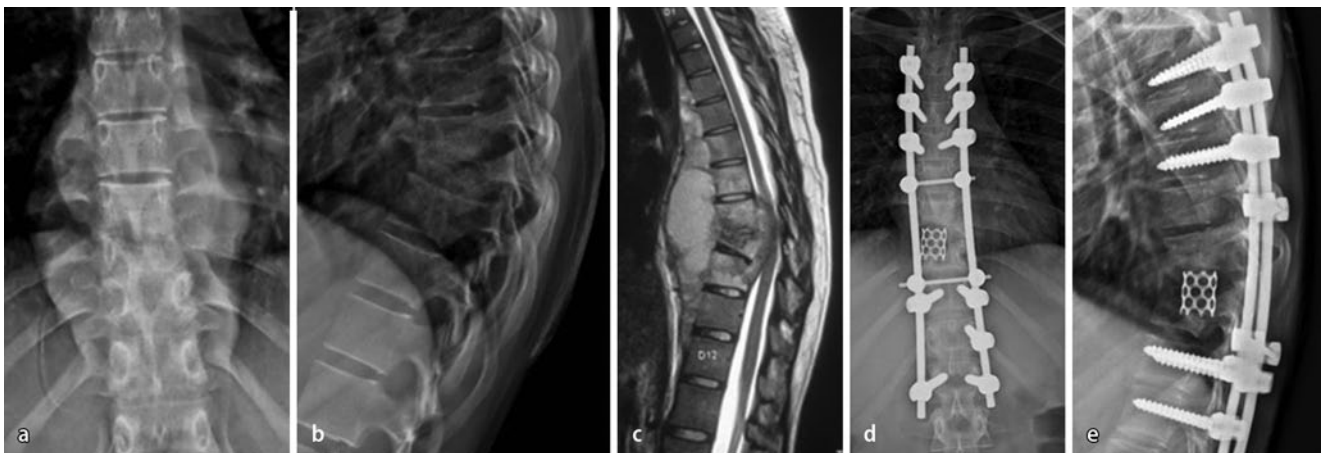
▲ a, b An 18-year-old girl with acute tubercular kyphosis seen as vertebral destruction and kyphosis from T7–9. c Sagittal MRI shows prevertebral abscess formation and epidural cord compression. d, e She was treated using posterior stabilization and anterior reconstruction through a costotransversectomy approach
